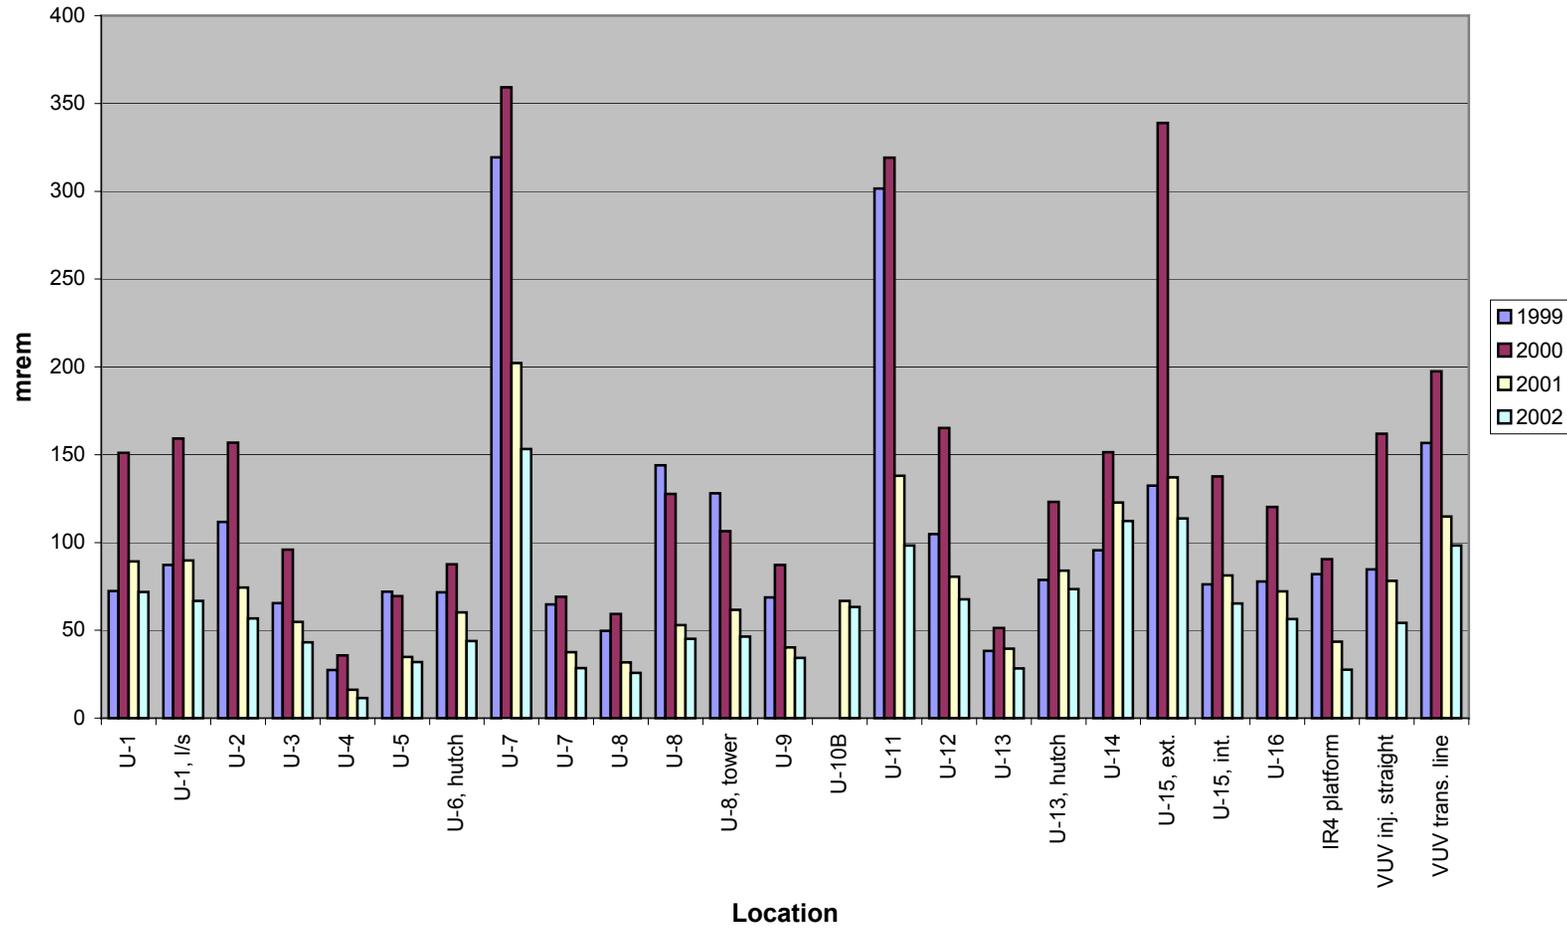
Area Monitoring Results for the X-Ray Ring 1999-2002
